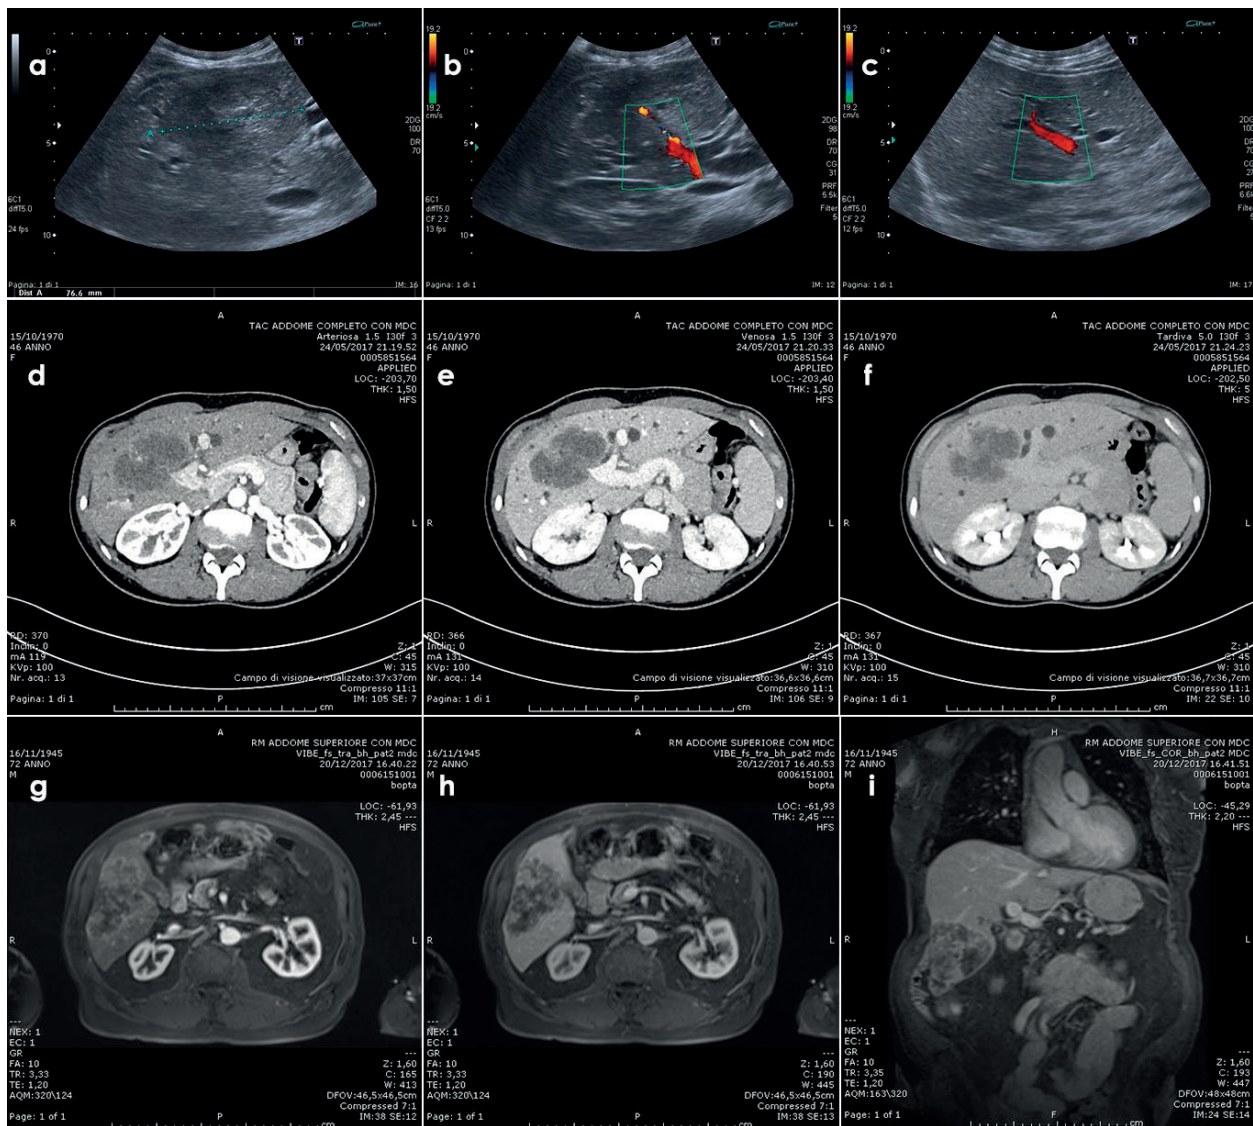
Mass-forming intrahepatic cholangiocarcinoma. (a–c) Abdominal ultrasound confirming the dilatation of intrahepatic biliary ducts, locating the site of obstruction. It appears as a homogeneous, hypoechoic lesion. (d–f) CT scan, the lesion is hypoenhanced, with capsular retraction and biliary dilatation. Right portal vein invasion can be noted. (g–i) MRI is characterized by peripheral enhancement followed by progressive centripetal filling.
